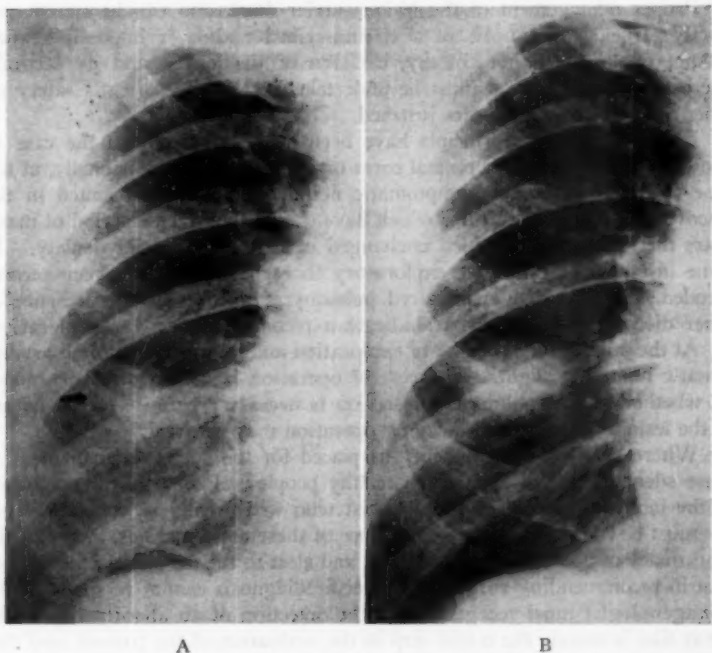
Case 11.* Small nodule in right lower lobe, October, 1950. Despite a request for further examination the patient did not return until April, 1951, at which time a slight increase in the size of the nodule was apparent. Although the patient's physician had received notification of the change, a recommendation for treatment was not made until an x-ray of November, 1951, showed further enlargement of the nodule.
